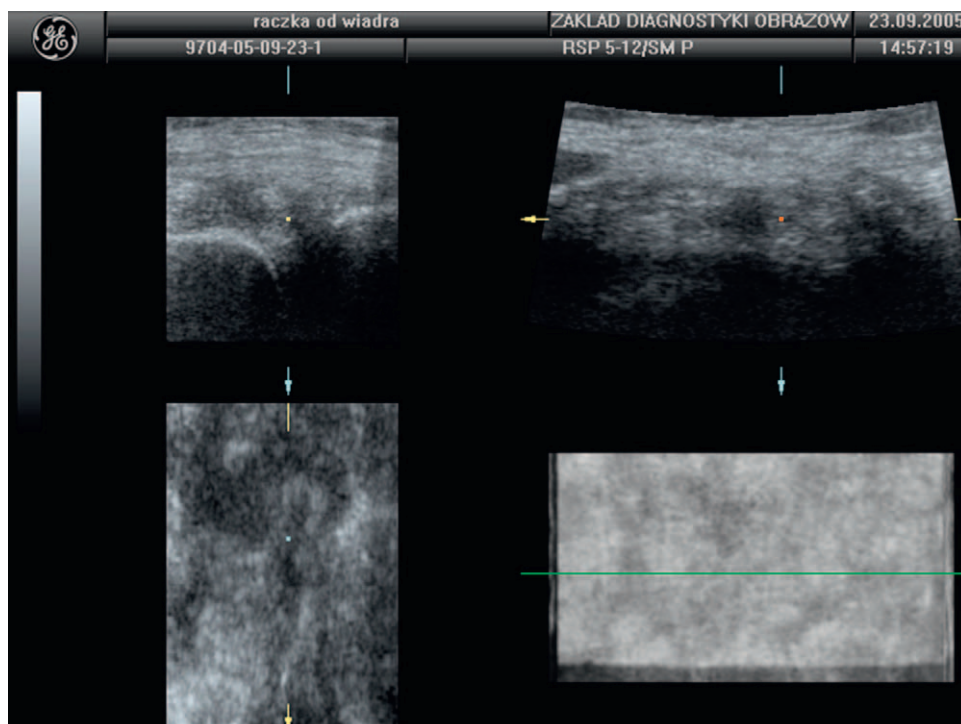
A bucket-handle tear of the medial meniscus demonstrated on three-dimensional ultrasonography (multi-planar reformation).
